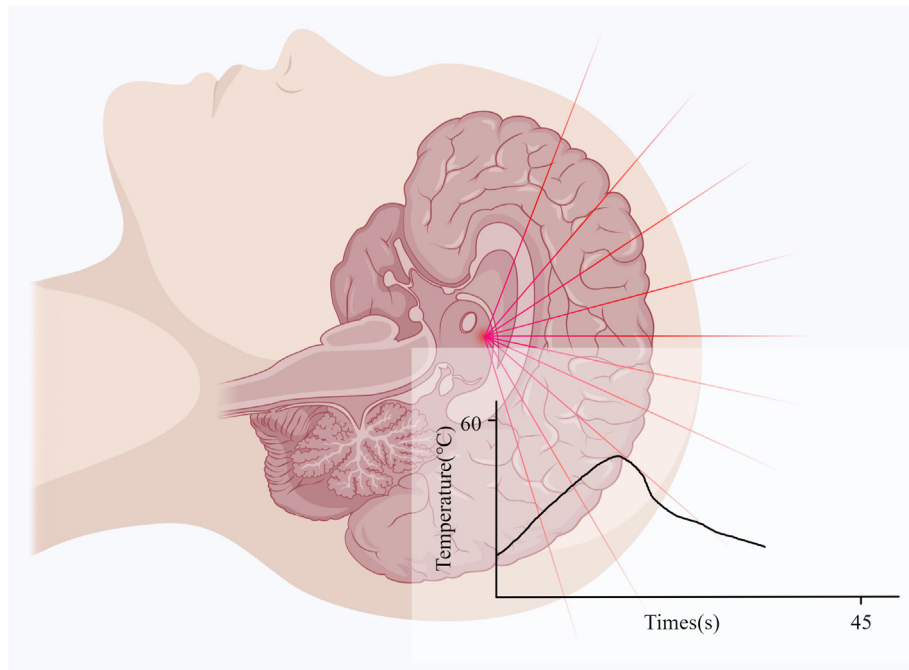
The mechanism of magnetic resonance-guided high-intensity focused ultrasound-induced thermoablation. High-intensity focused ultrasound enables sub-millimeter precision brain ablation.
